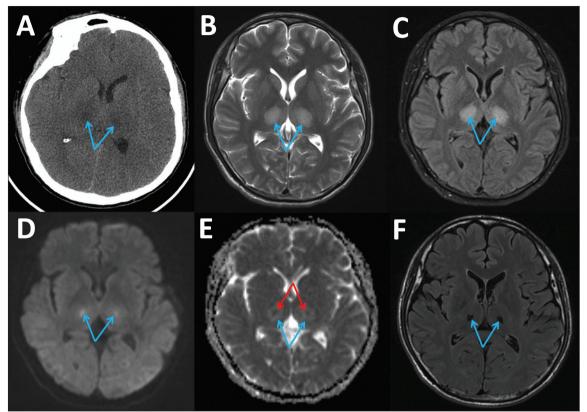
CT (A) and MRI (B: T2WI; C: FLAIR; D: DWI; E: ADC) showed symmetric lesions on the bilateral thalamus. DWI (D) revealed high signal intensity (blue arrow). ADC (E) revealed symmetric concentric thalamic lesions: reduced signal intensity in the core (red arrow), corresponding to diffusion restriction, and increased in the outer layer (blue arrow), corresponding to vasogenic edema and diffusion enhancement. The follow-up MRI-FLAIR showed low signal intensity in the core of the lesion in Panel E (blue arrow), which is indicative of iron deposition (F). ADC: Apparent diffusion coefficient. DWI: diffusion-weighted imaging; FLAIR: fluid-attenuated inversion recovery; MRI: magnetic resonance imaging.
